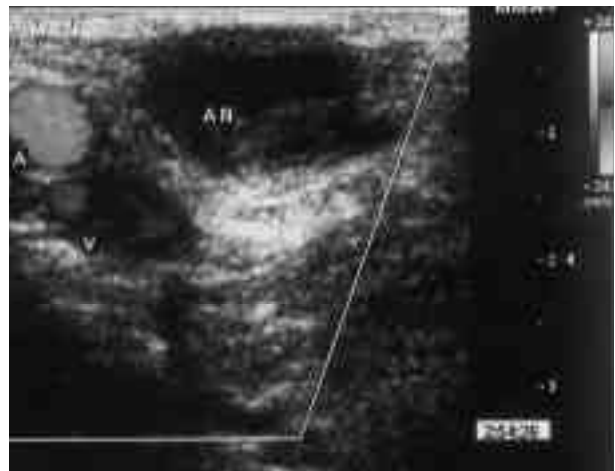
Post-ultrasound compression of left common femoral artery pseudoaneurysm, showing absence of arterial flow in the aneurysm
